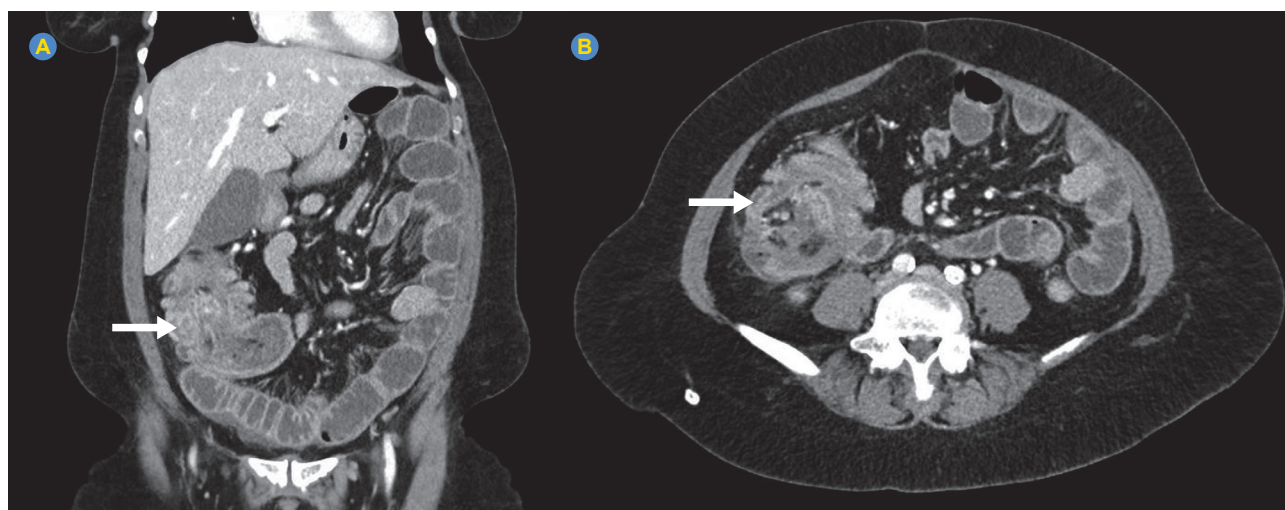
Abdominal computed tomography revealing ileocolic intussusception (arrows): (A) – coronal view; (B) – axial view.
